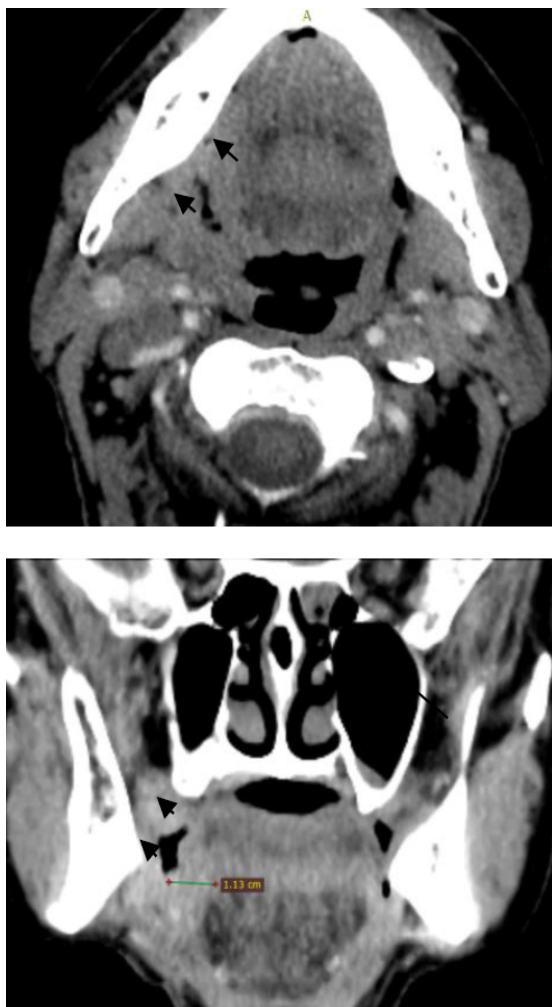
Squamous cell carcinoma of glossotonsillar sulcus a. Axial CT scan depicted spread into the retromolar trigone (small arrows); b. the figure also reveals the measurement of the depth of invasion (DOI) on the right base of the tongue.
